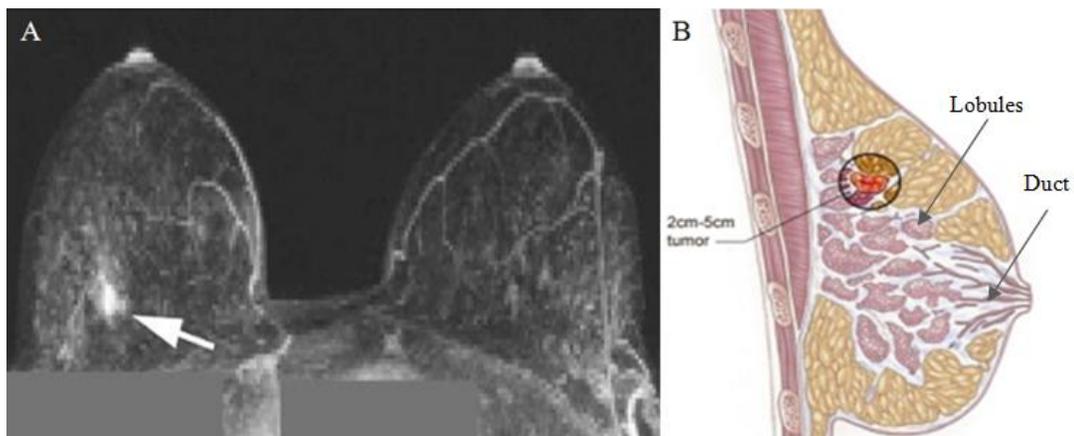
Common Breast Cancer Presentation (A) MRI of a solid breast tumor, depicted by arrow [adapted from Seewaldt, 2007]. (B) A classic sign of breast cancer is a hard, palpable lump [adapted from Akiavintage.com, 2011].
